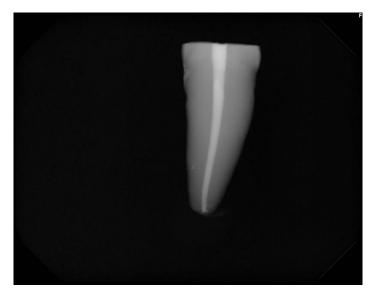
Post-op PA radiograph confirming complete obturation of the root canal with BC Sealer filling the terminal 3mm.
